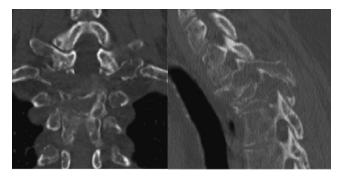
Coronal and sagittal CT images through lesion demonstrating significant osteolysis and regional kyphosis.
